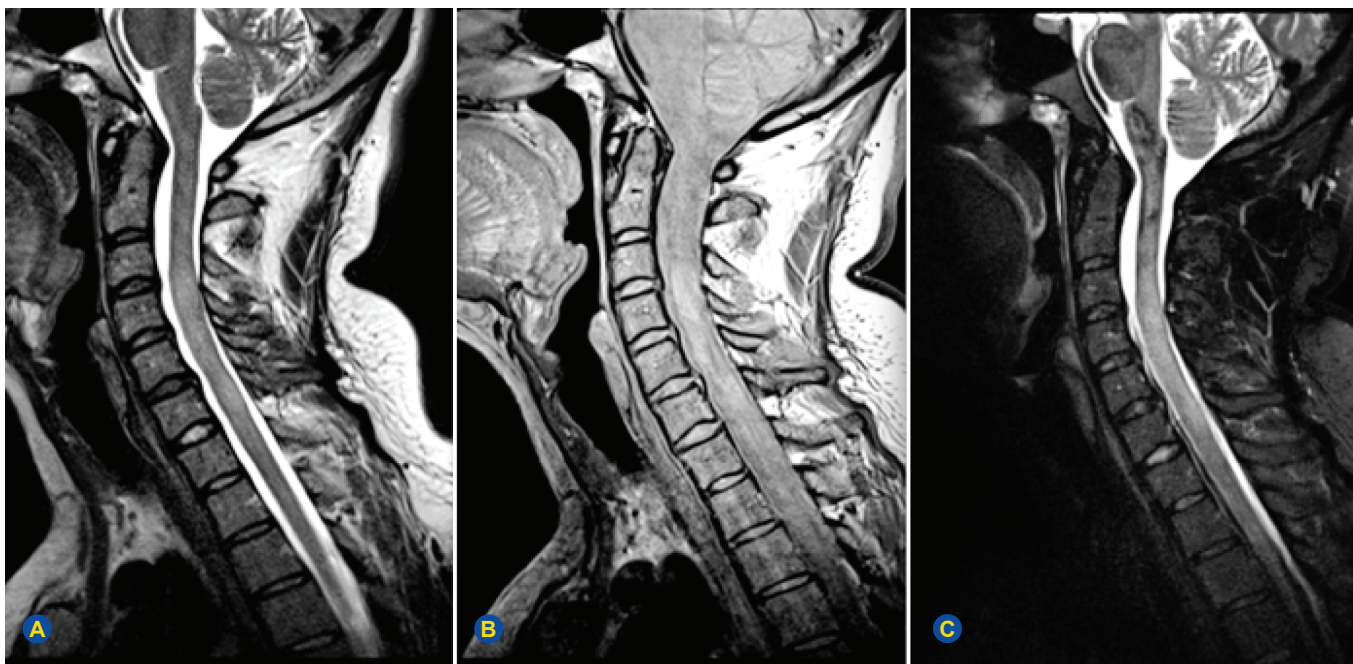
Sagittal cervical spinal cord images. (A) T2-weighted fast spin-echo. (B) Proton-density (acquired at dual-echo). (C) Short-tau inversion recovery (STIR). The images depict confluent cervical lesions in an MS patient extending from C2-C3 to C6. At least two T2 sequences are required to identify a demyelinating plaque at the spinal cord. Spinal lesions should also be confirmed on the axial plane.
